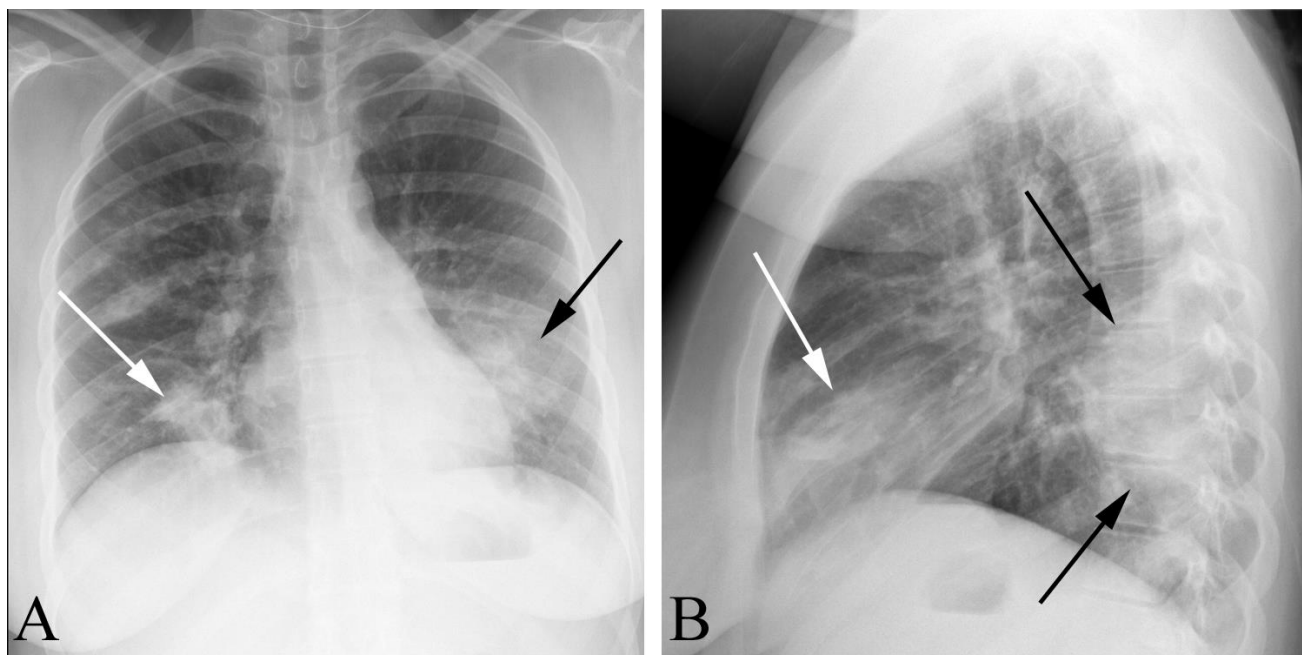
Alveolar pattern in a 15 year old with fever, cough, and bacterial pneumonia. A. PA chest radiograph shows focal abnormal densities in both the medial right base (white arrow) and along the heart border in the left base (black arrow). B. Lateral examination shows abnormal increased density overlying the heart (white arrow) and additional consolidation projecting over the mid thoracic spine (black arrows). Note that the vertebral bodies normally become more lucent from the apex to the base of the chest, whereas there is increased density of the mid-thoracic vertebrae in this patient.
